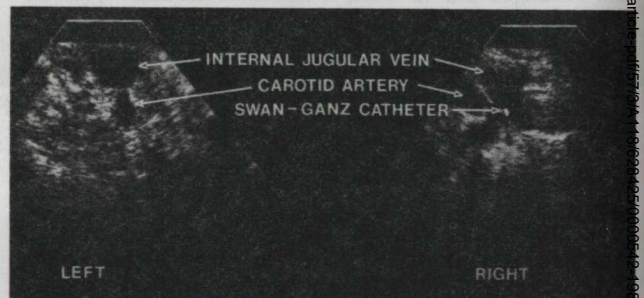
Ultrasound images of the right internal jugular vein cannulated with a PAC and the contralateral non-cannulated internal jugular vein.
